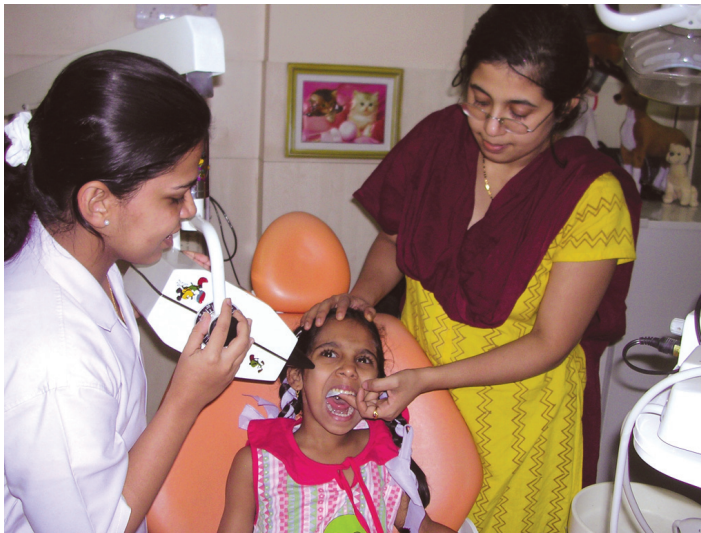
The child is now ready for the radiograph with mother's assistance
